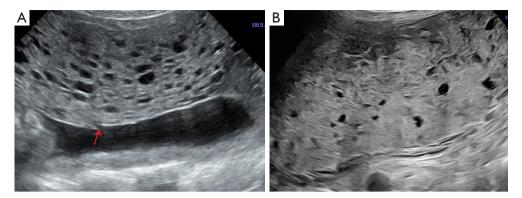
Case 1. (A) Ultrasound image at 24 weeks of pregnancy with PMD. Multiple honeycomb-like anechoic areas present within the placental substance. The red arrow points to the umbilical cord insertion site, and the affected region is located above the entrance of the placental umbilical cord. (B) Ultrasound image at 31 weeks of pregnancy with PMD. The placenta is significantly thickened, and cystic hypoechoic areas gradually decrease. The lesion partially covers the umbilical cord insertion site. PMD, placental mesenchymal dysplasia.
